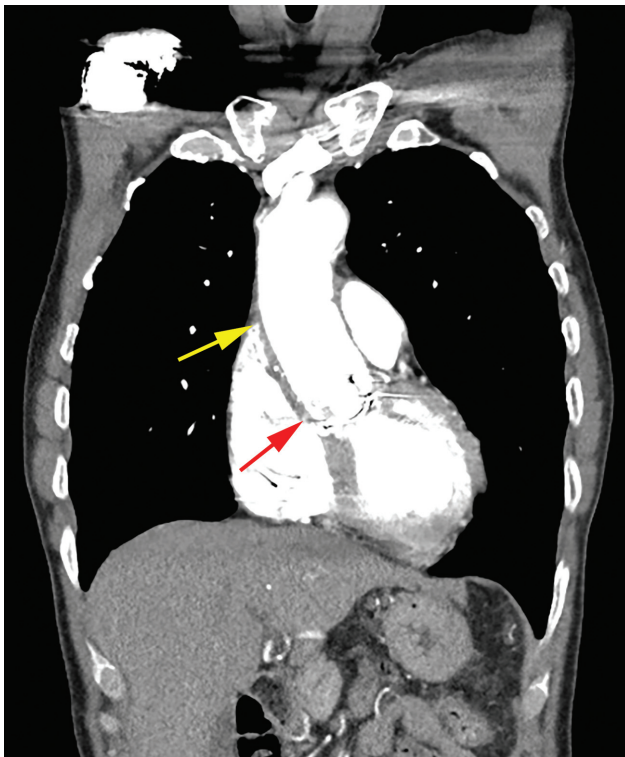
Chest computed tomography coronal view showing dilated aortic root (4.8 cm, red arrow) and ascending aorta (4.5 cm, yellow arrow).
